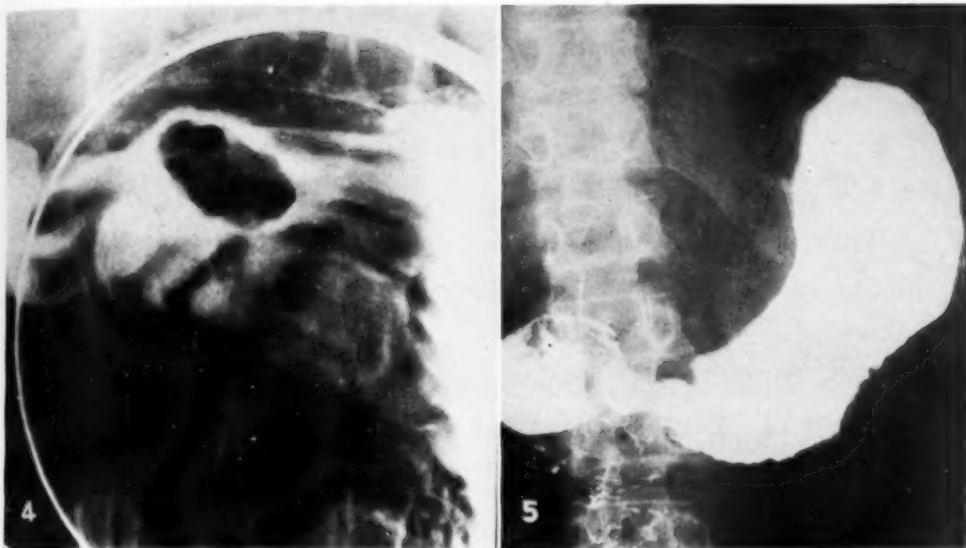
Case III. Roentgenogram of the distal third of the stomach made with compression under the fluoroscope. A moderately lobulated, sharply defined, oval filling defect in the antrum can be observed.
